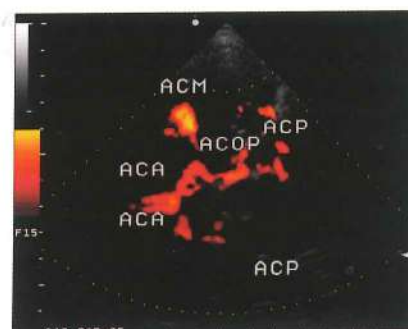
Circle of Willis visualized by TCCS power Doppler.
